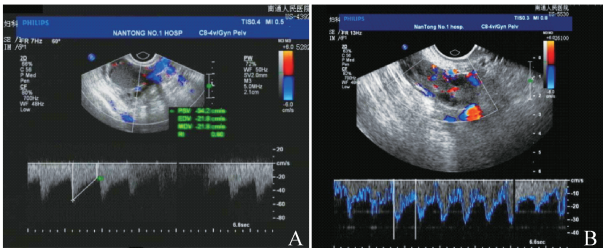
Color Doppler images in the two groups
